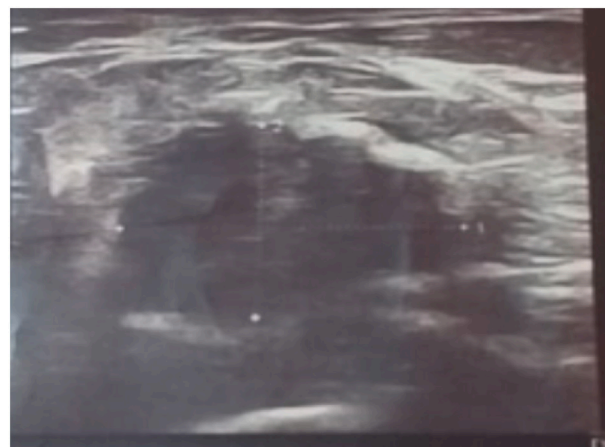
Sonographic appearance of the tumor.
